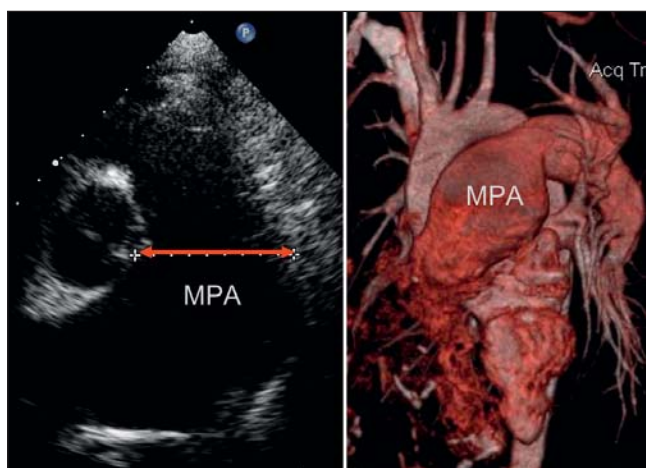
Echocardiographic and CT findings of severe central pulmonary artery dilatation (MPA – main pulmonary artery).
